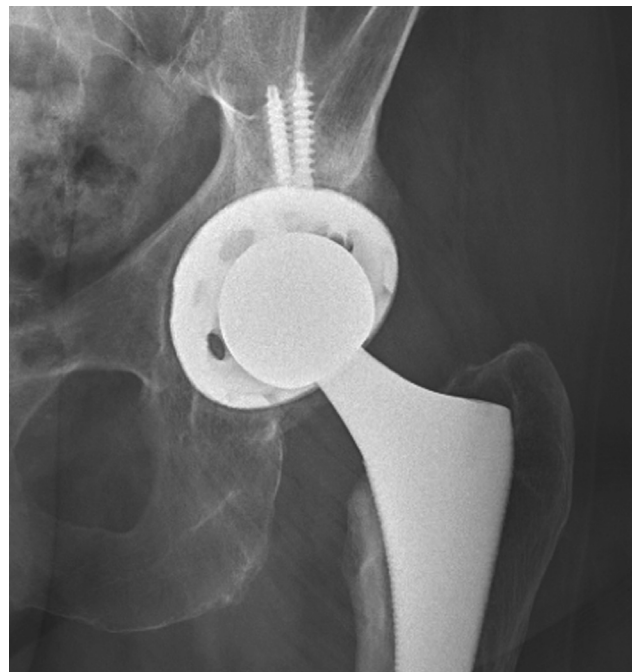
Anteroposterior hip radiograph of case 2 at 12 months demonstrating complete graft incorporation.
